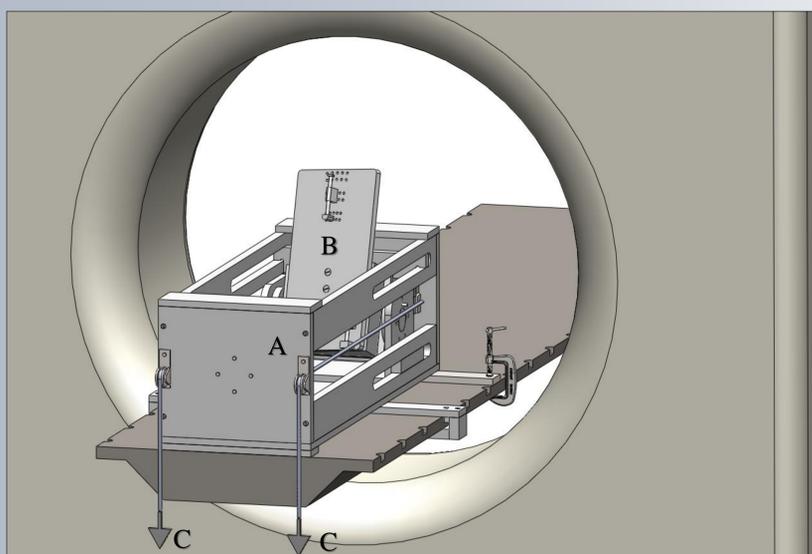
Test Frame Mounted on CT Scanner Bed: A) Test Frame, B) Ankle Positioner, C) Weights
